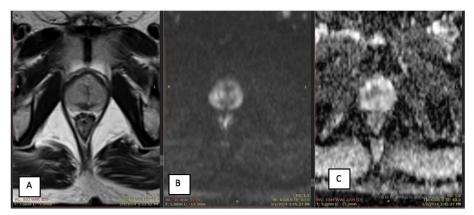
Figure (^{*}): axial T^{*} ill-defined area of hypo-intensity with definite borders (erased charcoal sign), B) axial DWI at high b-value & C) axial ADC shows marked focal diffusion restriction at the same area.
